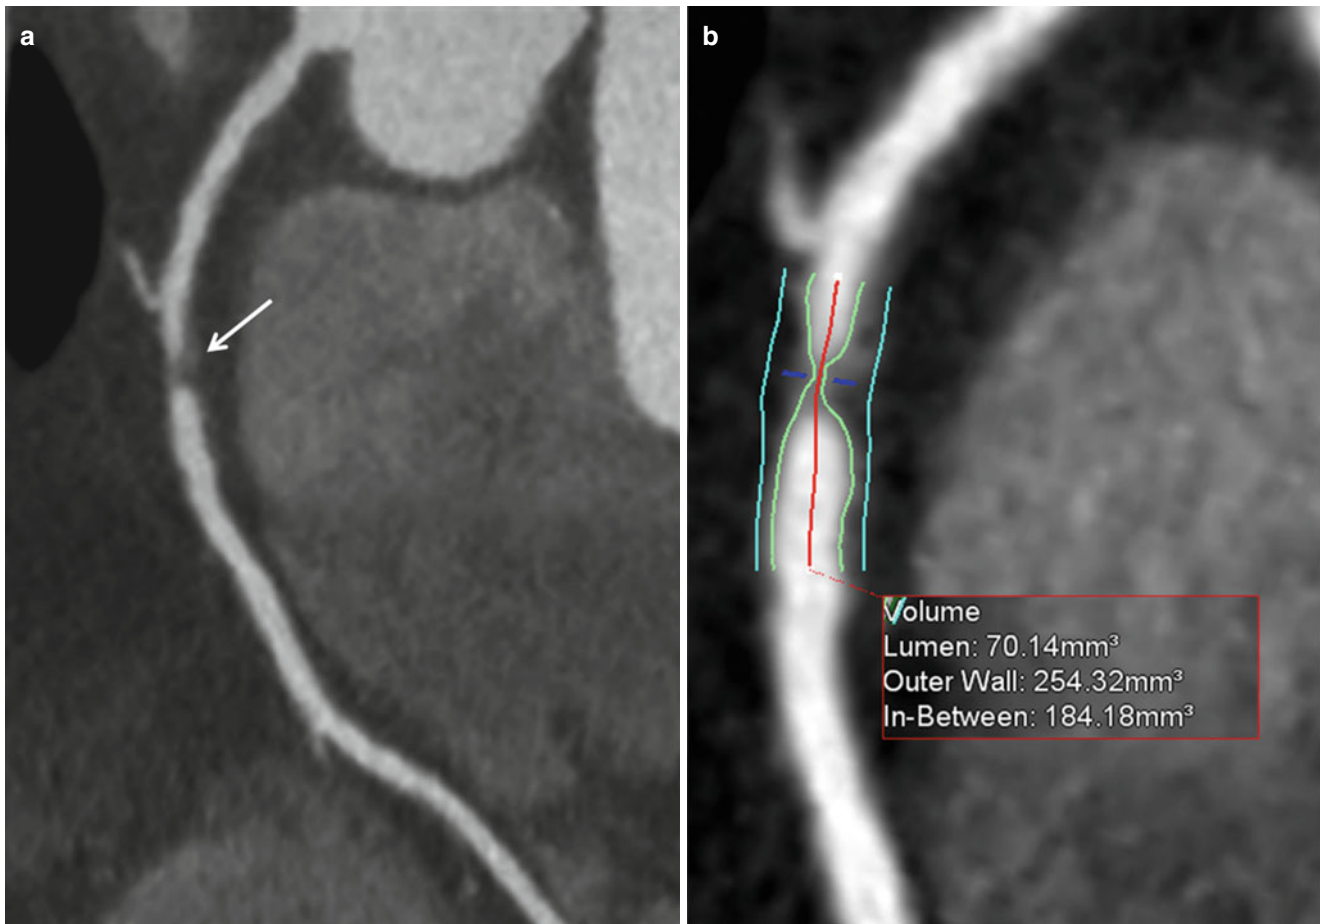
Quantification of plaque volume using coronary computed tomography (CCTA) with significant coronary artery stenosis of the right coronary artery (RCA). (a) Curved multiplanar reformatted (MPR) image of CCTA demonstrates significant coronary artery
